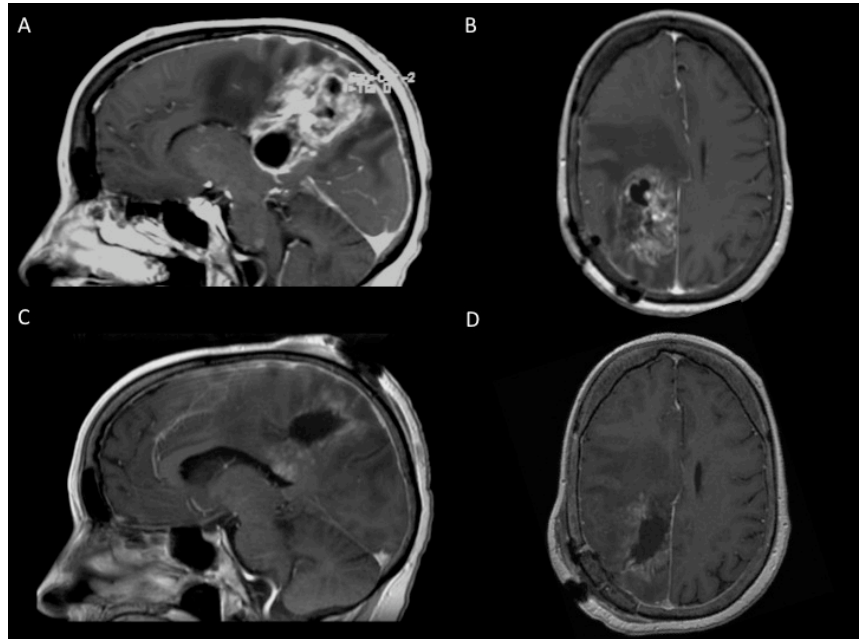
preoperative sagittal (A) and axial (B) T1 MRI w/ contrast shows a large tumor infiltrating the right parietal subcortical region with corpus callosum invasion. Postoperative sagittal (C) and axial (D) scans demonstrate the subtotal resection of the lesion.
